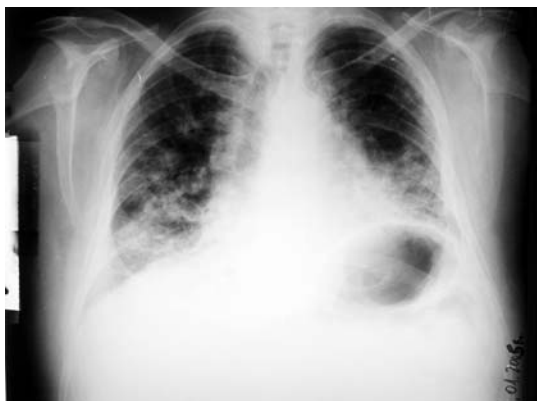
Admission chest X-ray. Status after partial resection of the left lung. Diffused ground-glass opacities in middle and inferior lung sections characteristic of pulmonary fibrosis. A small amount of fluid in the left thoracic cavity
